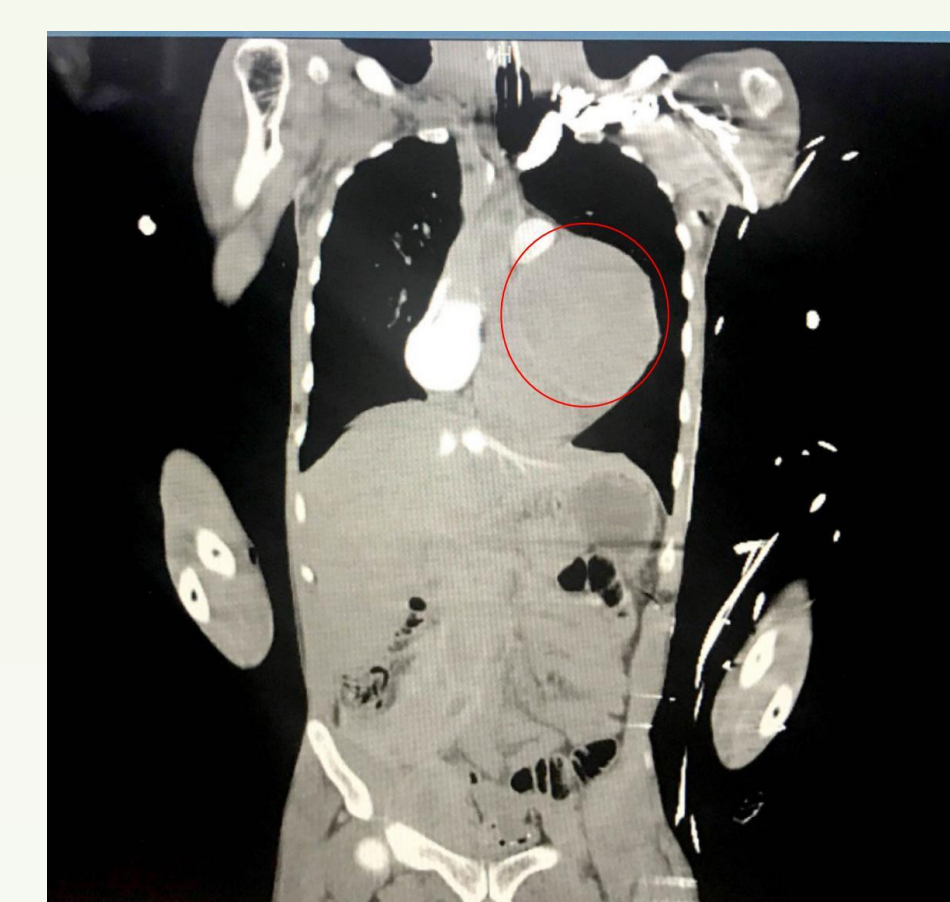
CT Angiography Chest, Abdomen and Pelvis – Frontal View: Very large left anterior descending aneurysm encircled in red. Cephalad to left ventricle and left lateral to aorta.
